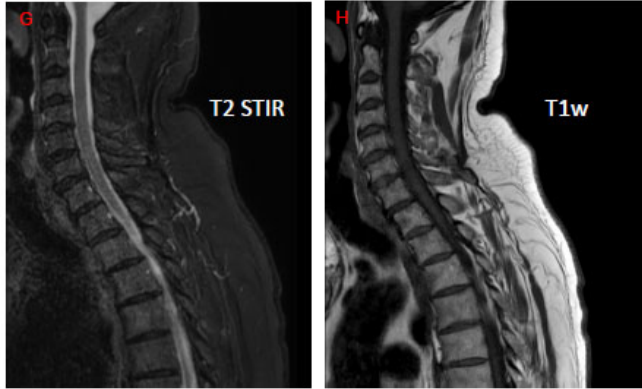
(A,C,E) ^{18}F -JK-PSMA-7 PET/low-dose CT on the left and (B,D,F) ^{18}F -PSMA-1007 PET/low-dose CT on the right of patient No. 27 with BCR. The maximum intensity projections (MIP) with ^{18}F -JK-PSMA-7 and ^{18}F -PSMA-1007 show two PSMA-positive lymph nodes right iliac and a PSMA-positive relapse below the bladder. Additionally, the ^{18}F -PSMA-1007 PET scan shows a further relapse localization at the junction between the bladder and the urethra (B). The osteo-medullary spots in the cervical spine (C3, red arrows in B,D) and thoracic spine (Th 5, red arrows in B,F) did not have any correlate on the MRI scan (G,H).
